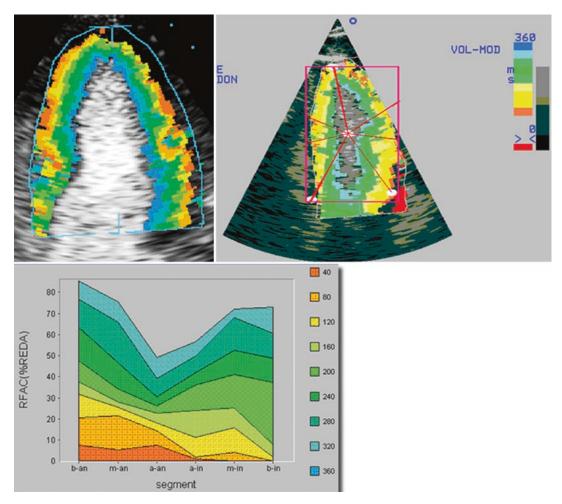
Quantitative Contrast Colour Kinesis (Philips Medical Systems) images showing an apical 4 chamber view at the top left with contrast in the LV cavity and coloured bands overlaid on the image representing systolic excursion of the endocardium. Thicker colour bands represent more systolic excursion of the corresponding segments. The scan plane has been semi-automatically
